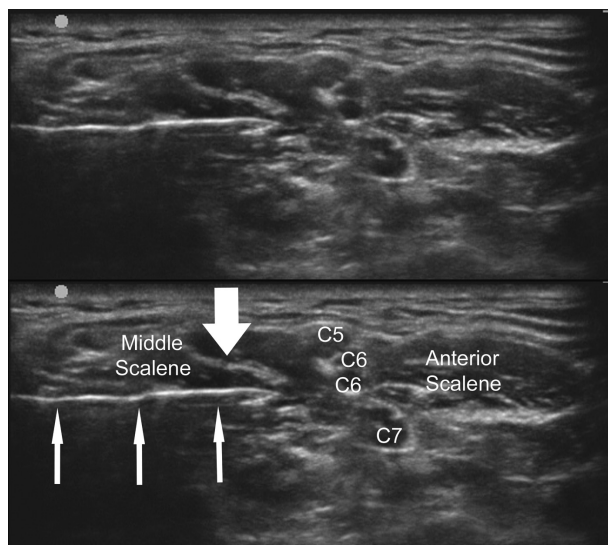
Sonogram showing stimulating Tuohy needle (small arrows) inferior to a dorsal scapular nerve (large arrow), within the middle scalene muscle, and posterior to the brachial plexus. Right side of the image is medial/anterior.
